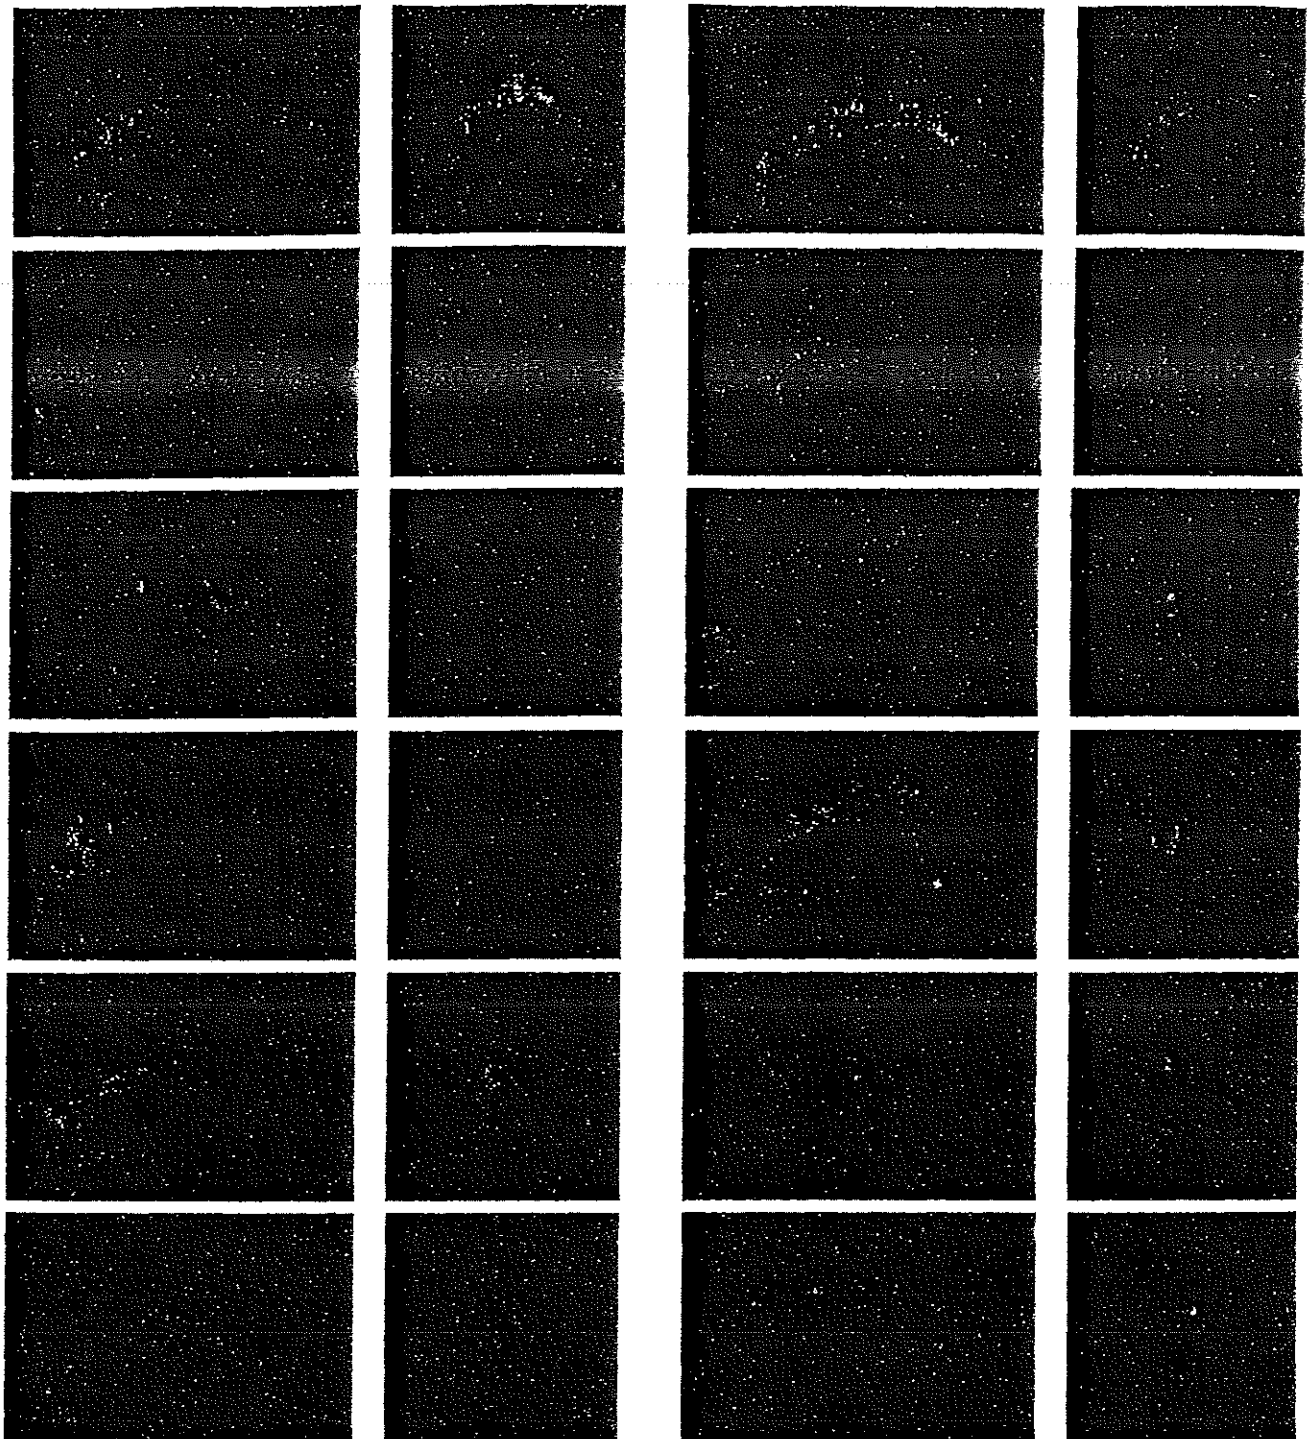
Lateral view for the tractography of the corpus callosum (left column) and fornix (right column) in a control (left upper) and in 11 patients with traumatic brain injury. The tractographs are overlaid on T2-weighted MRI.
